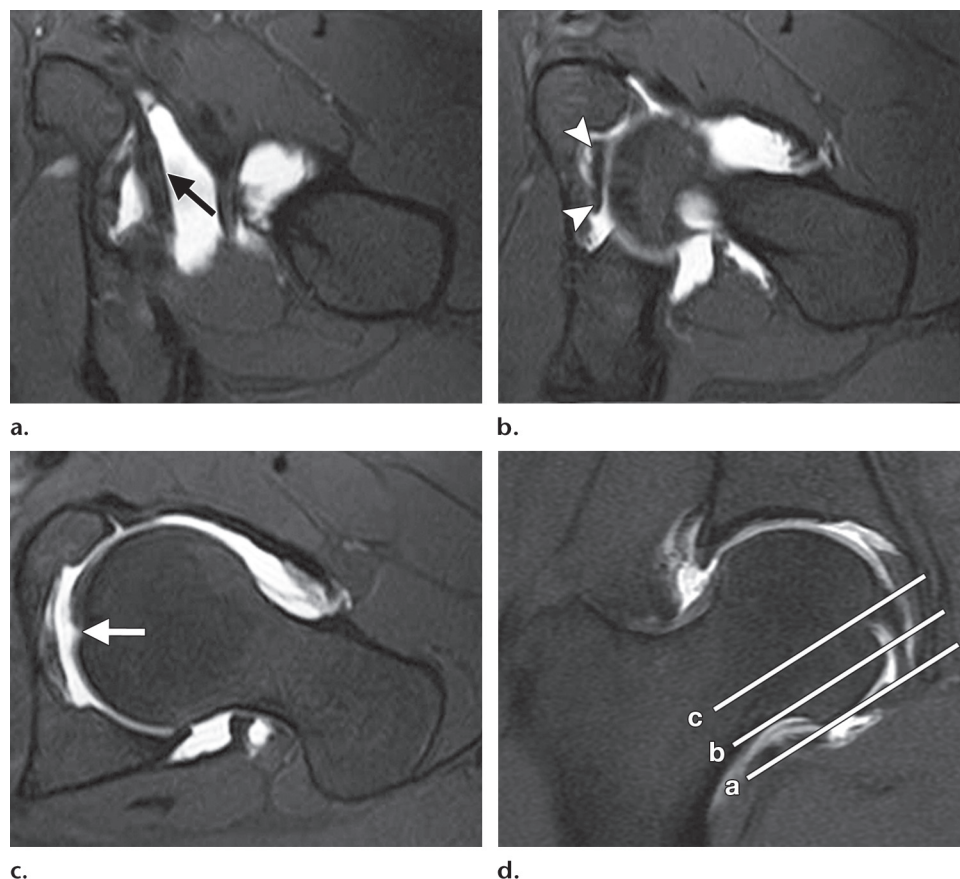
Normal anatomy of the ligamentum teres. (a–c) Consecutive oblique axial T1-weighted fat-suppressed MR arthrograms show the acetabular transverse ligament (arrow in a), the middle one-third of the ligamentum teres (arrowheads in b), and the insertion of the ligamentum teres into the fovea capitis femoris (arrow in c). (d) Coronal T1-weighted fat-suppressed MR arthrogram shows the levels at which a–c were obtained.
